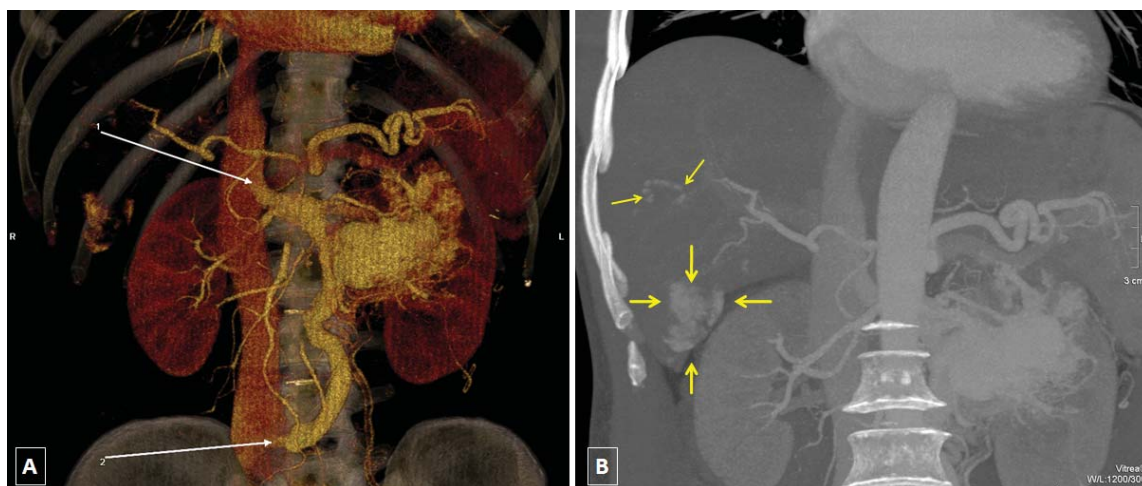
Contrast CT image (panel A) showed network of blood vessels at the upper pole of the left kidney and draining to supra- (arrow 1) and infra-renal (arrow 2) segments of the vena cava inferior. There were revealed two hemangiomas (arrows) in the right lobe of the liver (panel B).
